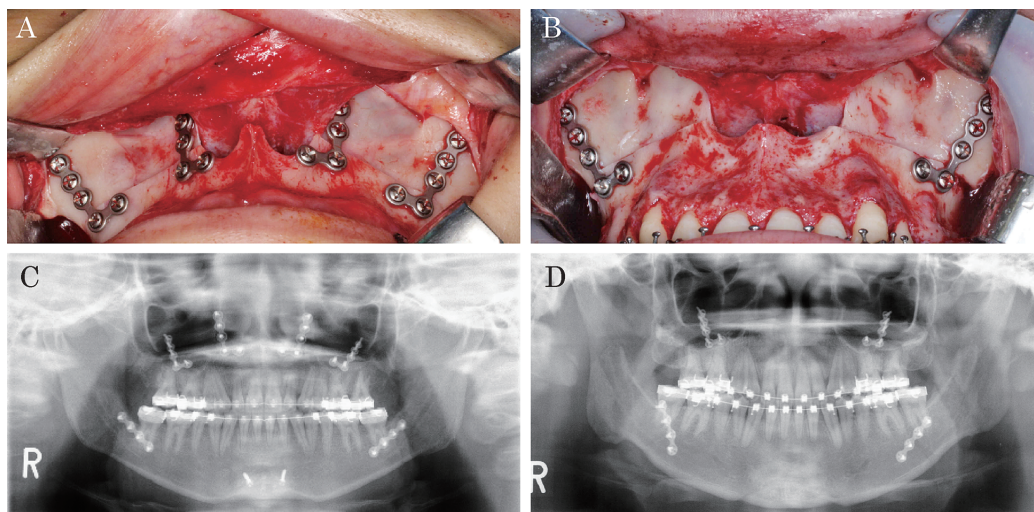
Intraoperative photograph and X-ray after surgery
